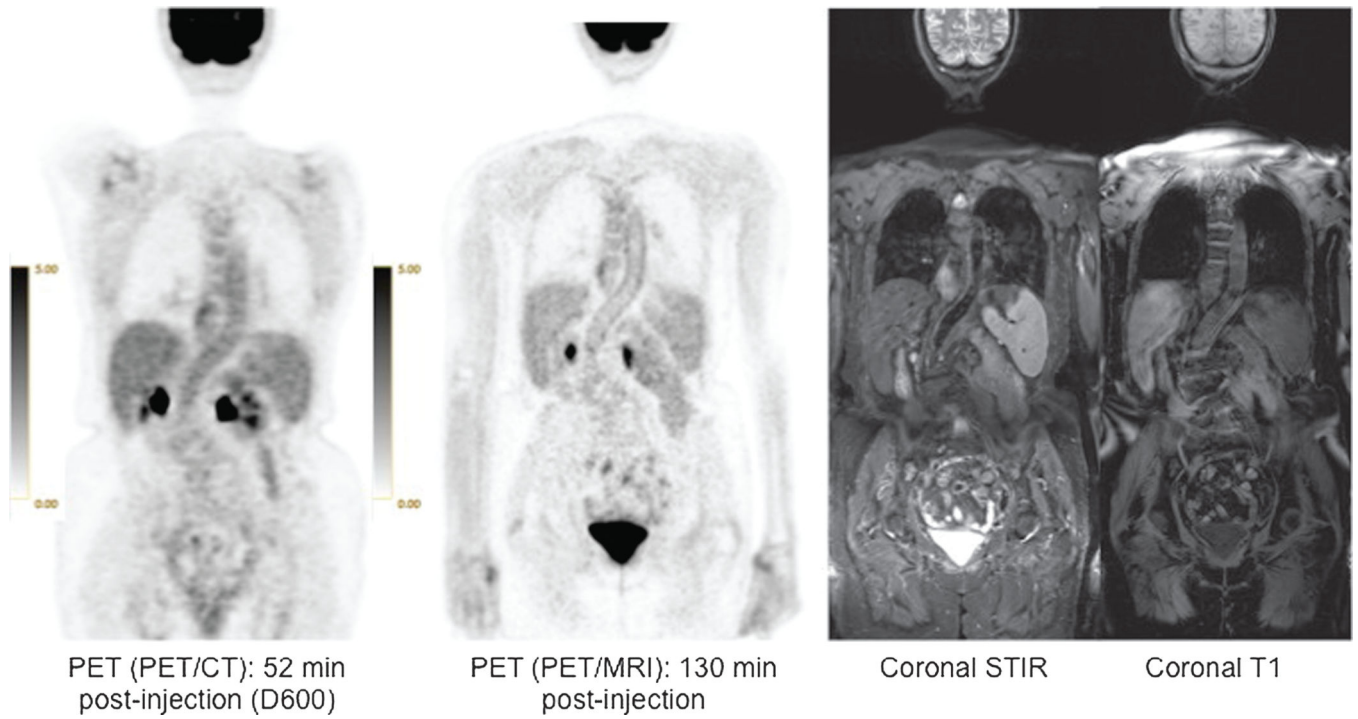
79 year-old woman with lymphoma. High definition of thoracic and abdominal aortic walls (arrows) is noted on PET from PET/MRI. Corresponding coronal STIR and T1 MR images are also shown.
